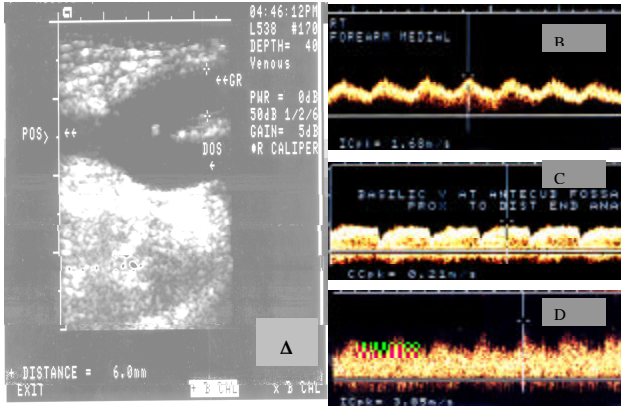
Ultrasonic B-mode scan of a dialysis patient's graft-to-vein junction (A) and ultrasound velocity measurements in the graft (B), DVS (C) and PVS (D).
